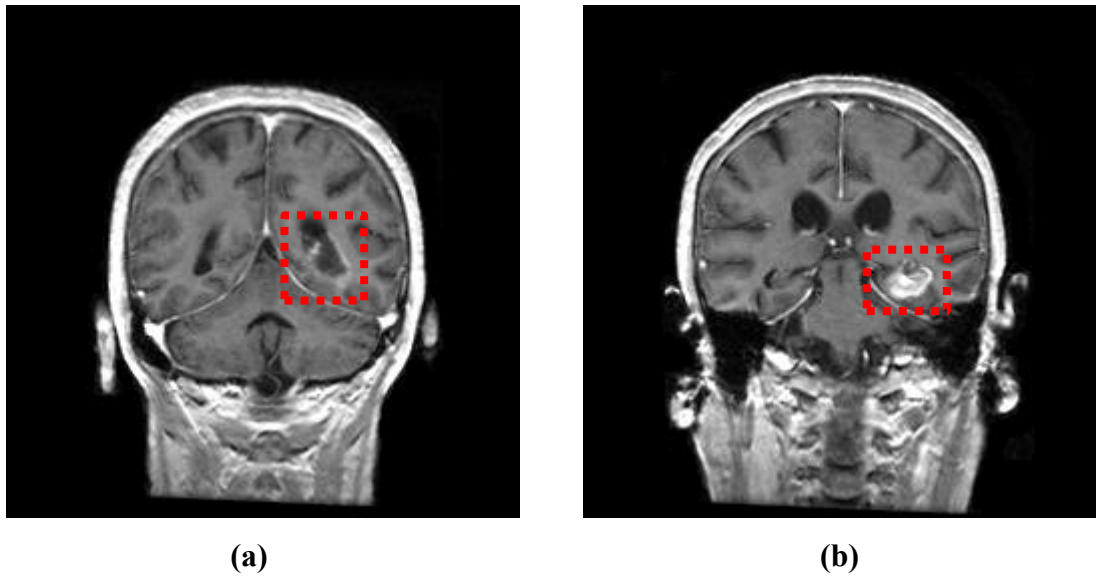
Abnormal MRI slices at different locations with varying size, shapes, and image intensities of brain tumour (red rectangle) from IBSR (536_T1) dataset of MRI scan 536_32, (a) Slice 22, and (b) Slice 26
